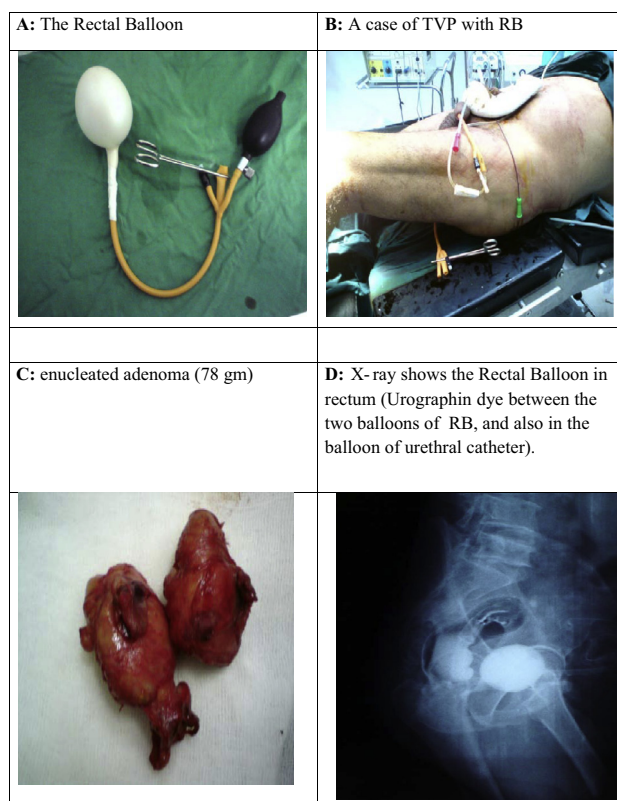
(A) The RB assembled ready for use. (B) A patient undergoing TVP with the RB in situ. (C) An enucleated adenoma (78 g). (D) A radiograph showing the balloon in the rectum (with contrast medium between the two balloons of the RB, and in the balloon of the urethral catheter).
